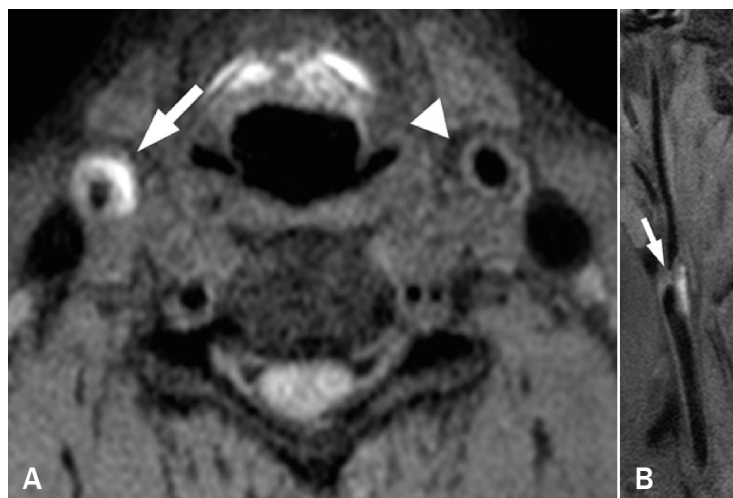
Magnetic resonance imaging, T1 3D black-blood sequence. The plaque to the right on the axial plane (A) presents hypersignal in T1 compatible with hemorrhage, while the left side plaque presents hyposignal, compatible with protein/collagen component. Image on the sagittal plane of the right-side plaque (B) demonstrates the extent of plaque hemorrhage.
